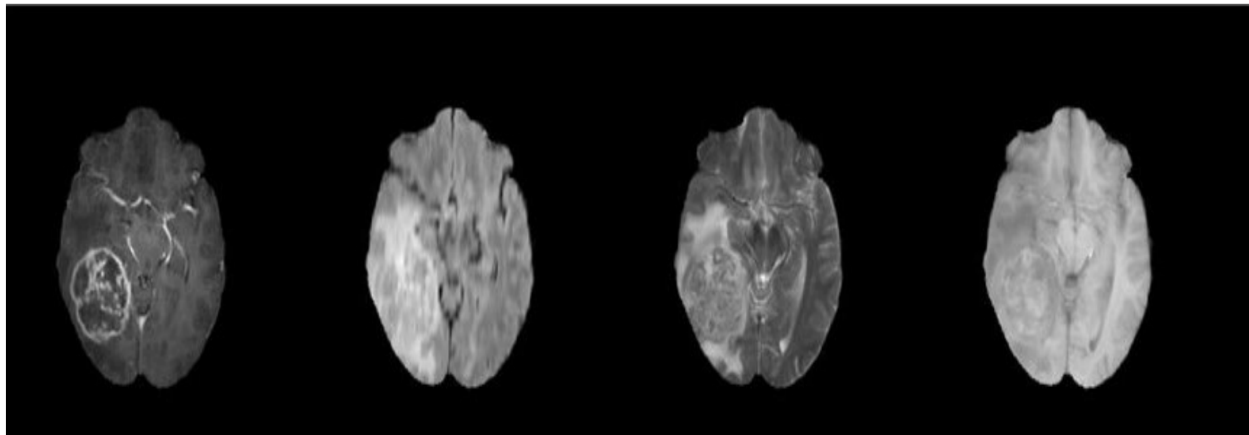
Example of brain MRI data from the BraTS2018 dataset. From left to right: FLAIR, T1, T1-c, and T2
